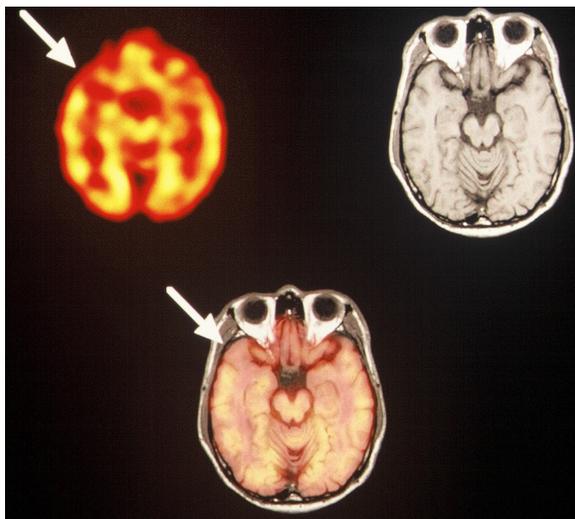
Brain perfusion SPECT image registered with respect to corresponding high resolution anatomical image.
